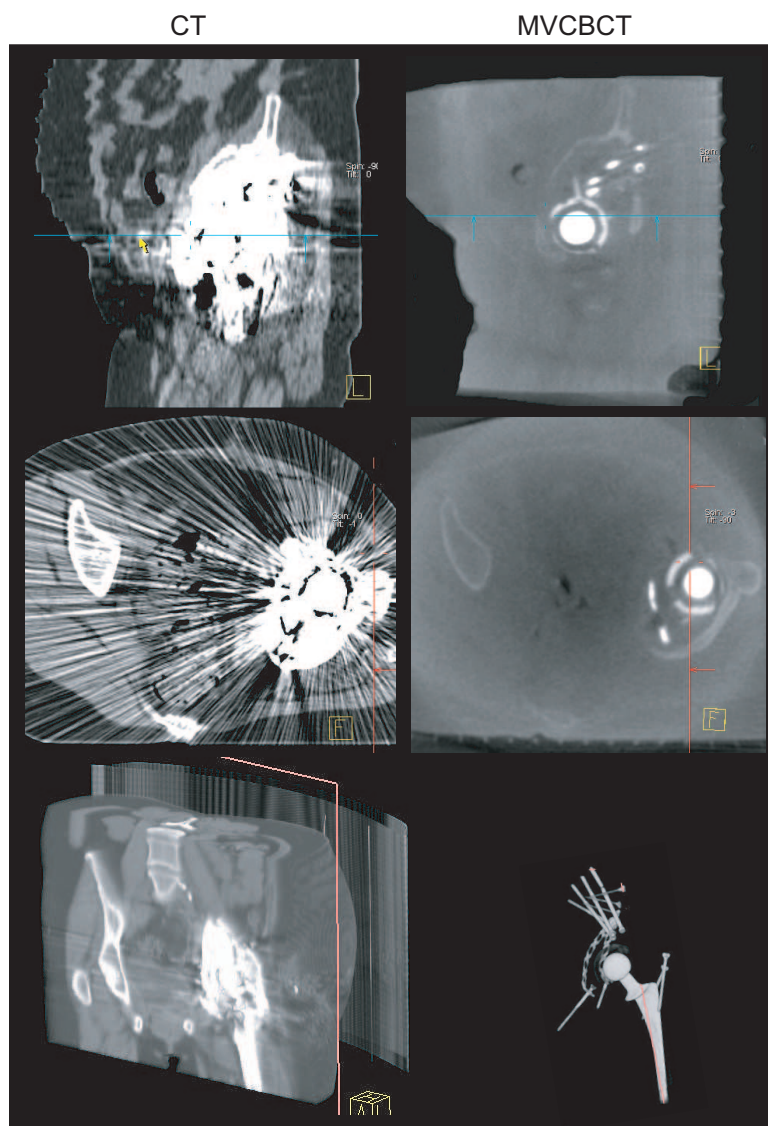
Images showing the superior performance of MVCBCT (right) over CT (left) in the presence of dense metal objects. All metal pieces used for this hip reconstruction are clearly visible on the MVCBCT 3D rendering (bottom).
